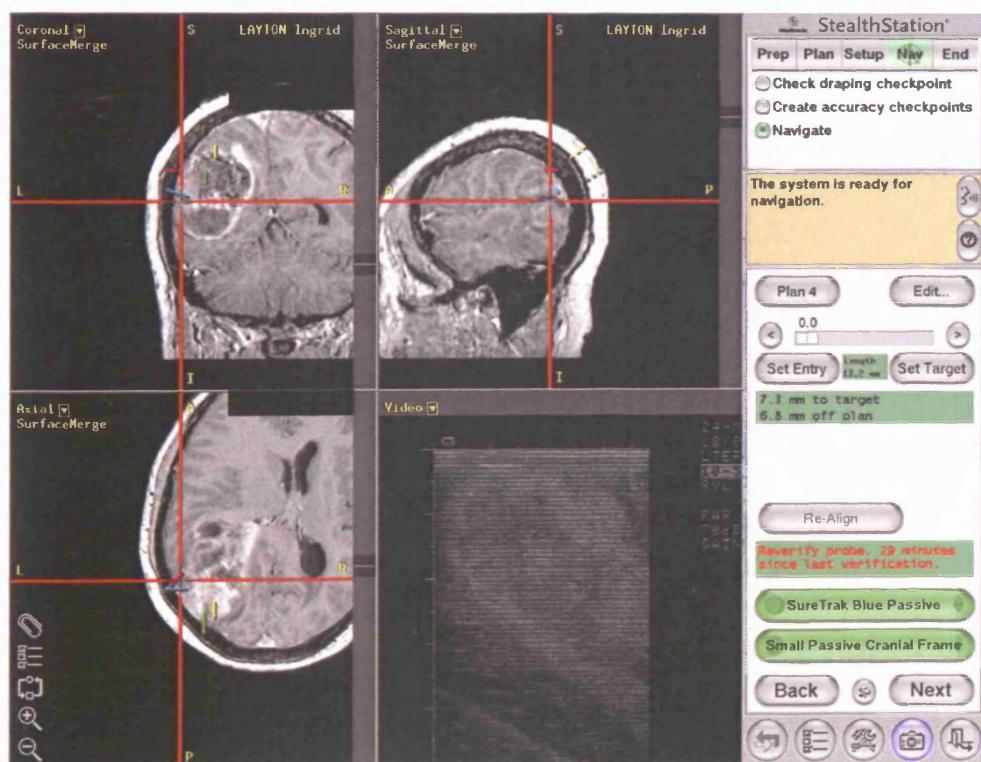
StealthStation™ screenshot of patient 4 demonstrating how the tumour heterogeneity seen on MRI is likely to be related to stiffness heterogeneity
